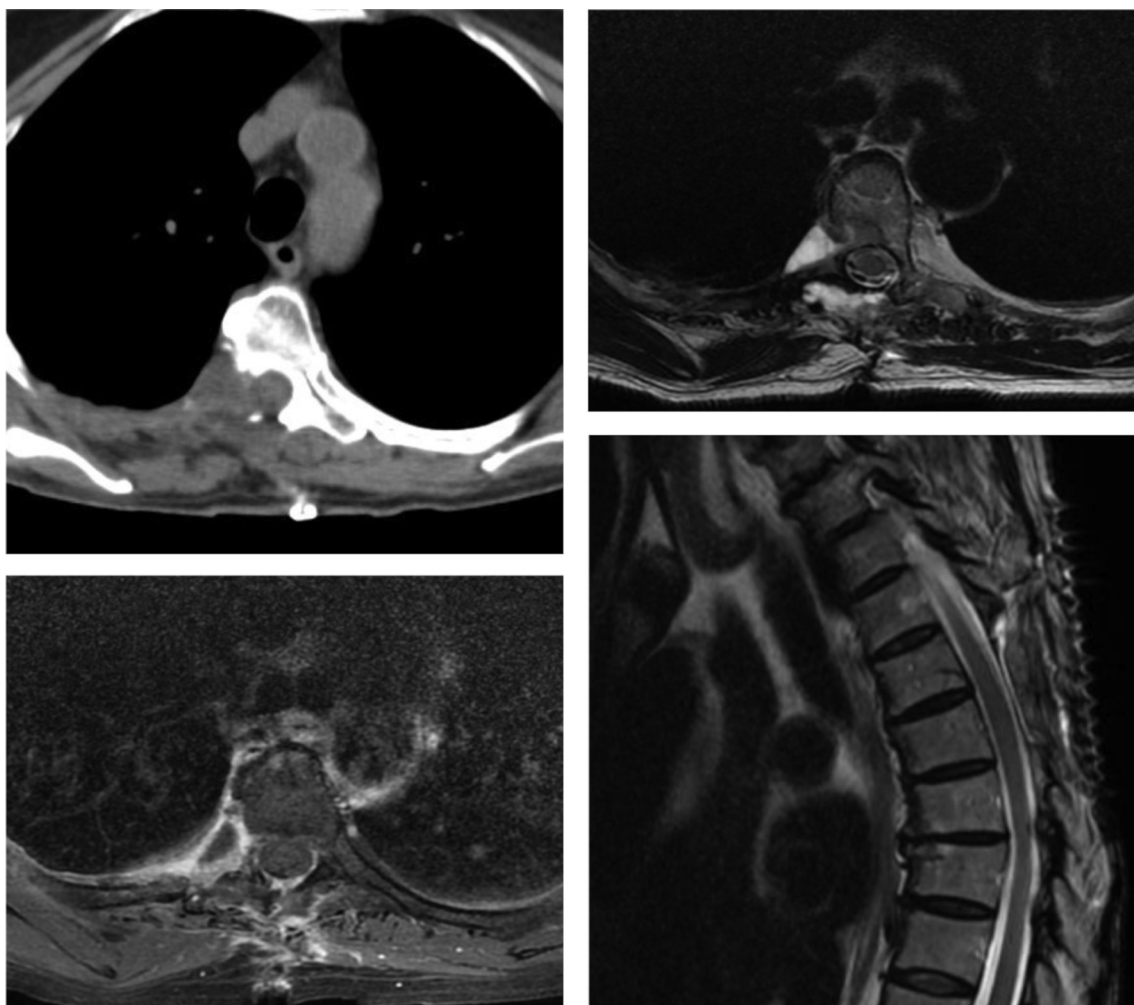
Early post-operative MRI and CT scan.
